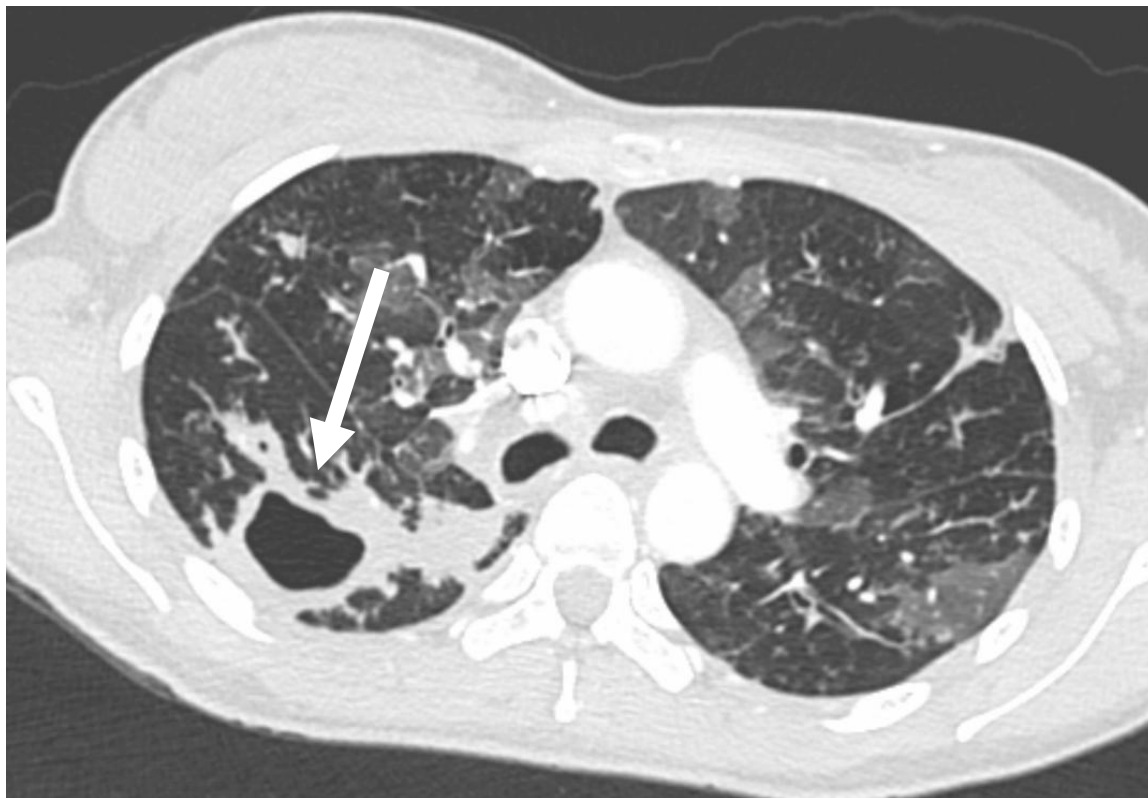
CT scan of the same patient in figure 1.11. Note the large cavity in the upper right lobe (indicated by arrow). Courtesy of Dr. Marc Lipman, Royal Free Hospital, London
